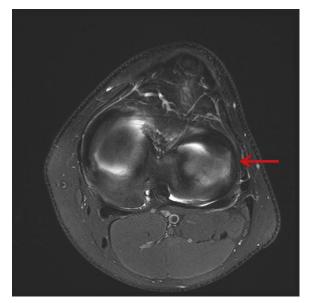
T2-weighted axial image of the left knee at 6 months postoperatively showing interval healing of radial tear of lateral meniscus (arrow).
